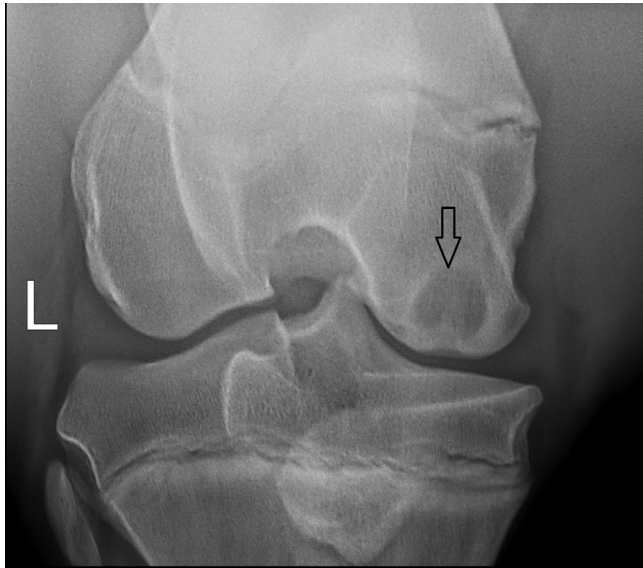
Radiograph of a Grade 3 MFC SCL from a young Thoroughbred. The “L” denotes the lateral side of the stifle. The arrow indicates the proximal border of the bone cyst.
